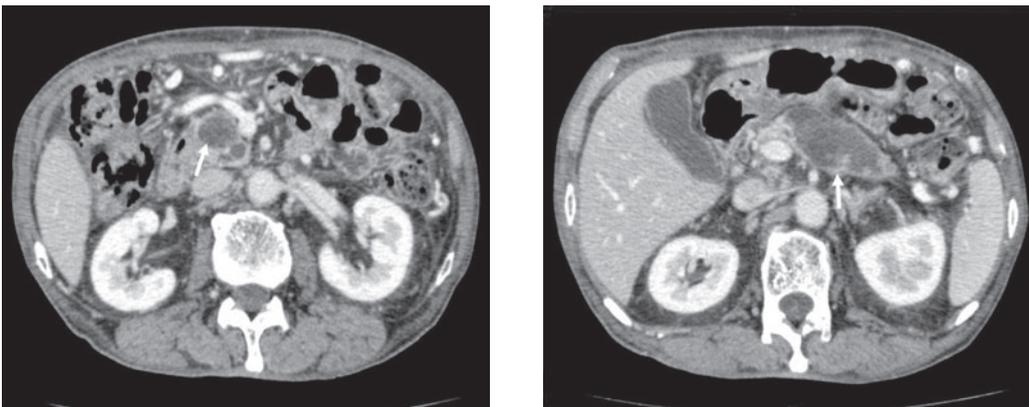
and 1B : CT shows low density cysts in the pancreas head (A) and body (B).
